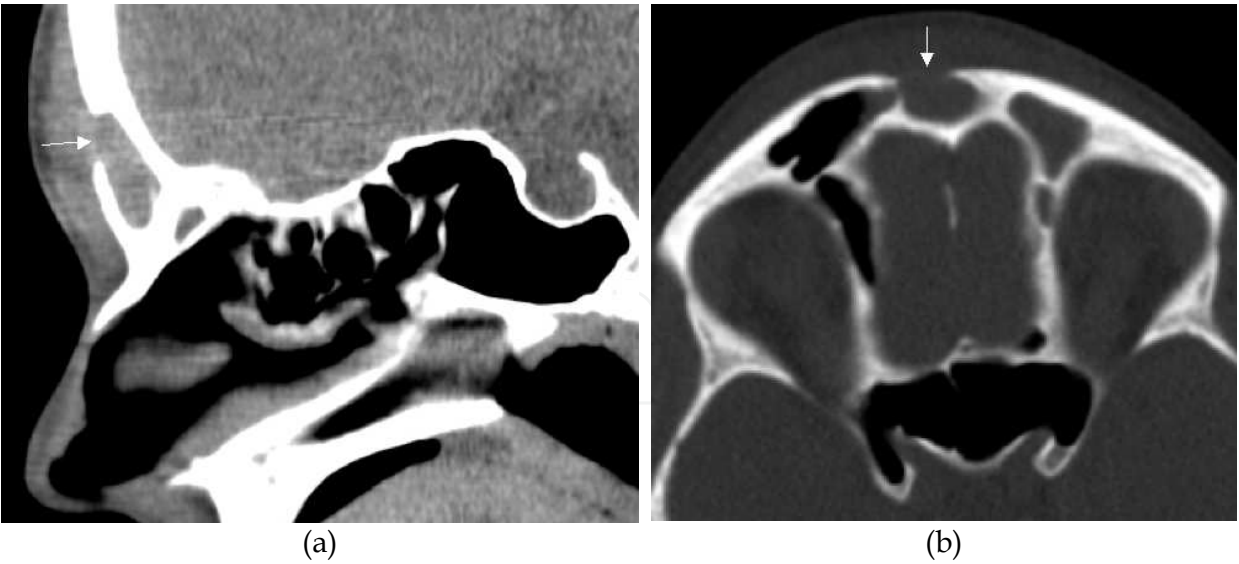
(a) Sagittal CT shows total opacification of the frontal sinus with erosion of the anterior wall (arrows) due to an eroding frontal sinus abscess, referred to as Pott’s puffy tumour. (b) Axial CT in the same patient
